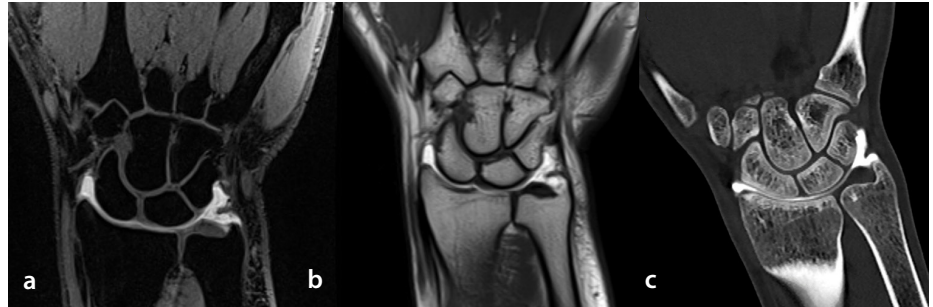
Coronal plane T1-weighted VIBE, TSE T1, and multi-detector CT arthrograms of the radiocarpal joint clearly reveal the cartilaginous surface, joint capsule, and triangular fibrocartilaginous complex. VIBE, volumetric interpolated breath-hold examination; CT, computed tomography.
